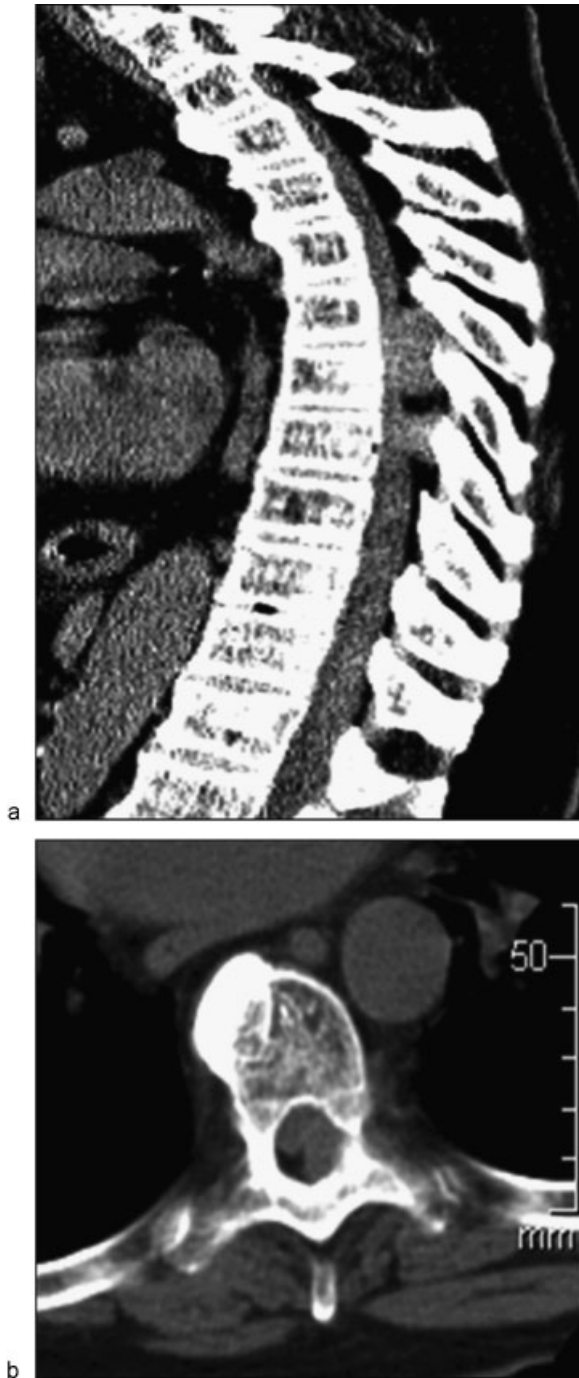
(a) Sagittal CT of the thoracic spine shows bilobed tumor at T6–T8. (b) Axial CT shows tumor compressing the spinal cord.
